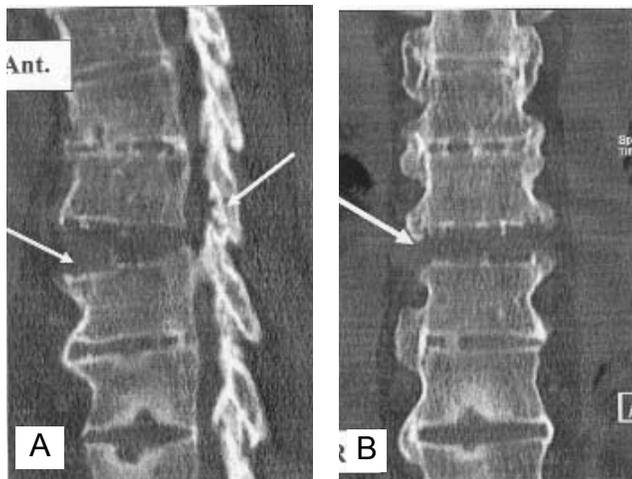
Sagittal (A) and coronal CT reconstruction (B) of the thoracic spine, showing the extension-distraction injury at T8-9 (arrow) which is extending all the way to the posterior column (arrow). Note the increased osteophytes on the right side of thoracic spine compared with the left side, a characteristic feature of DISH.
